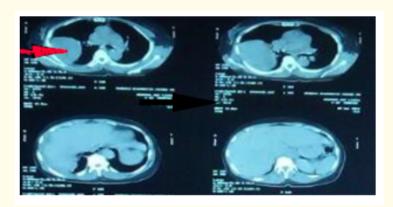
Preoperative CT chest showing a solid mass in the right hemithorax.
